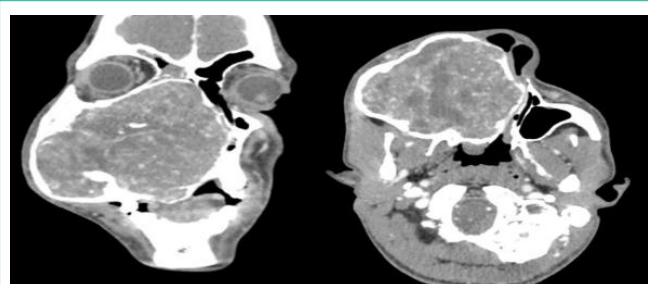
CT scan shows expansile lesion with cortical thinning and focal breach.
